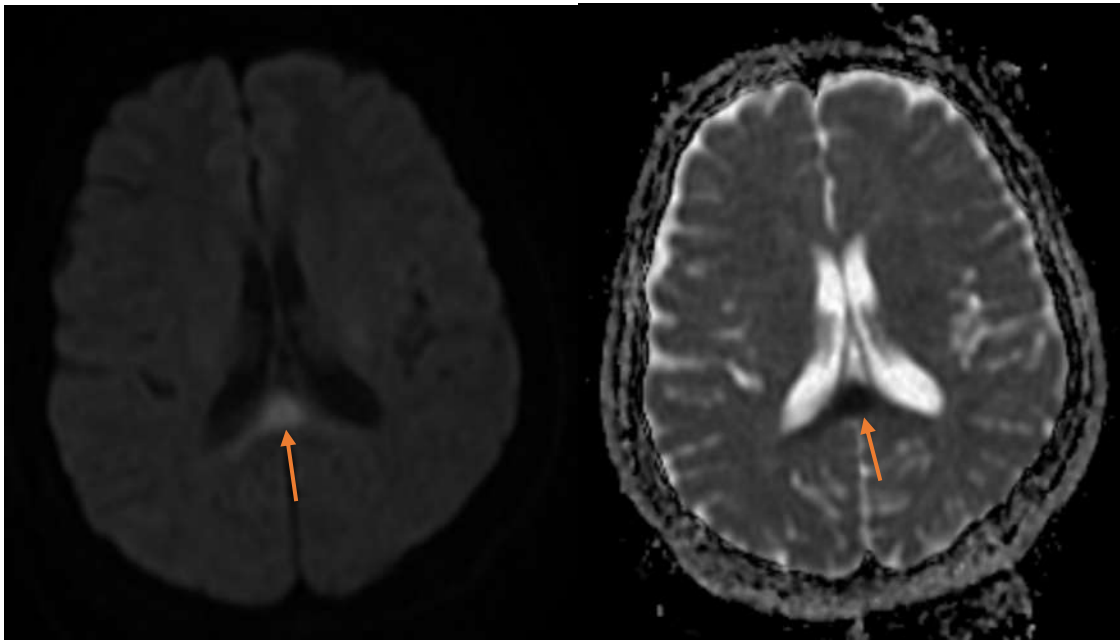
Diffuse restriction area in the corpus callosum on diffusion MRI imaging and its counterpart in the ADC sequence
